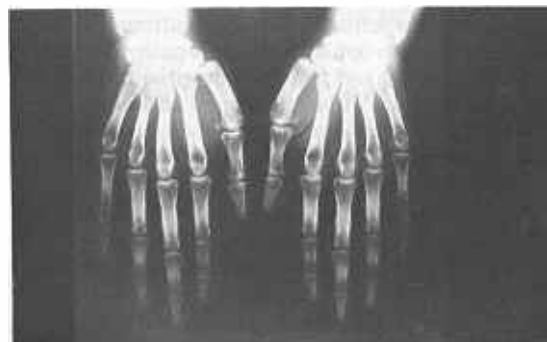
X-rays of hands showing periosteal new bone formation in the shafts of the right 2nd, 3rd and 4th metacarpals and proximal phalanges.
